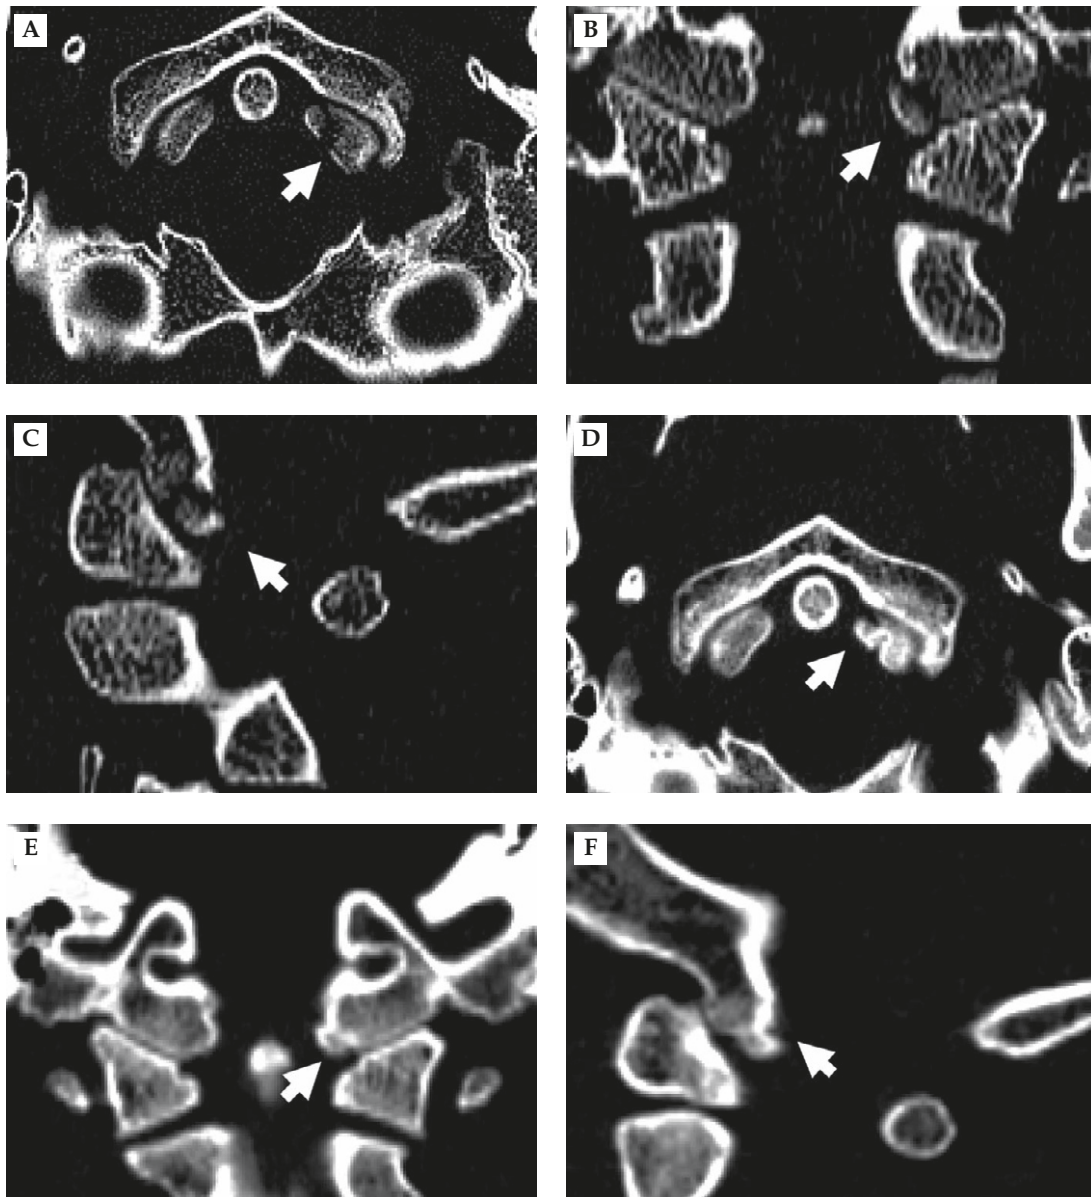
Computed tomography (CT) images of the patient with occipital condyle fracture. (A) Initial CT scanning revealed a bony chip from the left occipital condyle (arrow). (B, C) Reformatted CT images showed no medial displacement of the chip (arrows). (D–F) At the follow-ups, CT imaging examinations revealed that a healing process had occurred at the fractured site 18 weeks after the insult (arrows).
